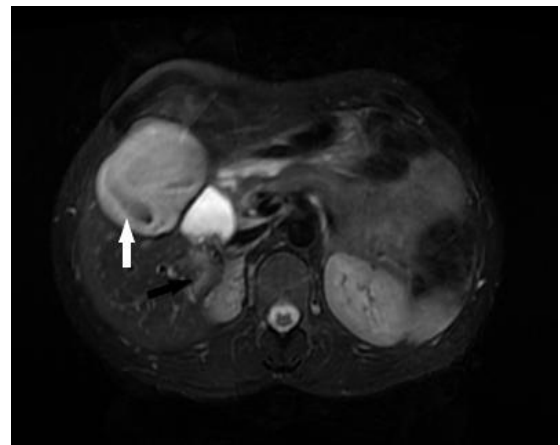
Magnetic resonance image (MRI) of the lesions
